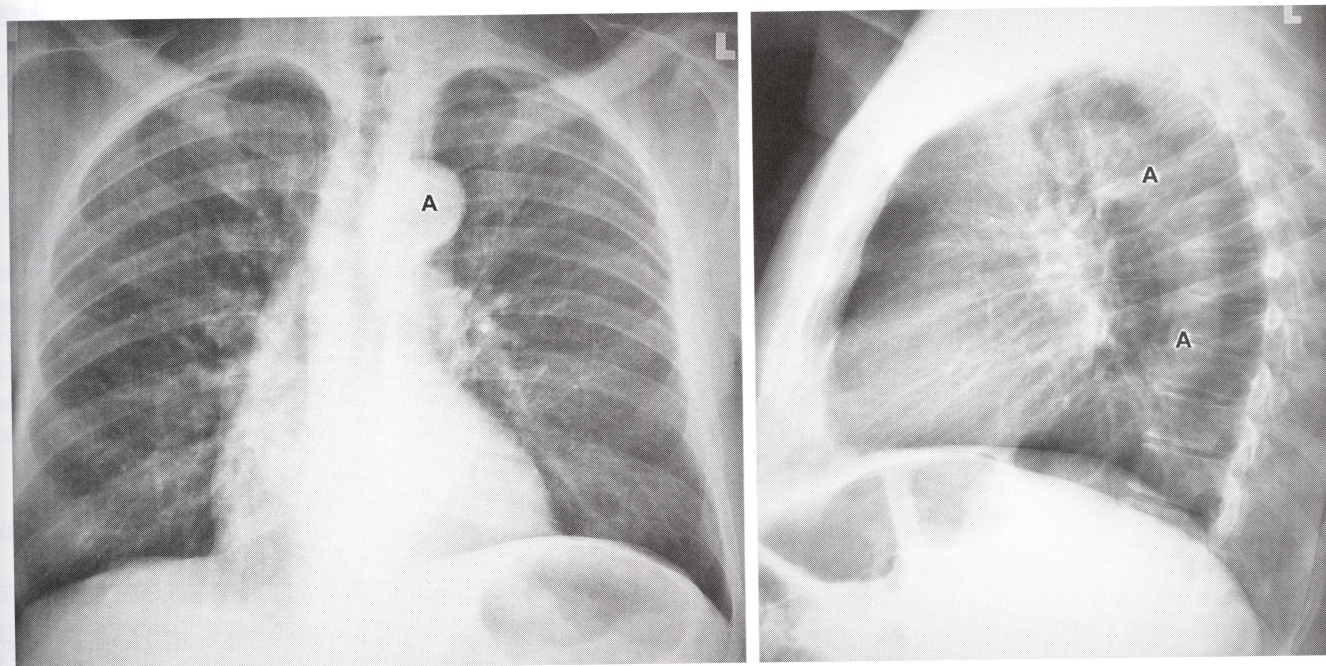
Normal PA and lateral radiographs in an elderly adult—Tortuous aorta.
